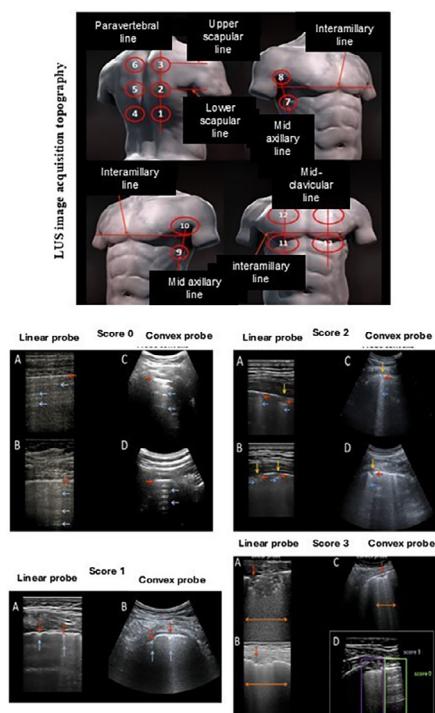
Epidemiological and clinical history data. Qualitative data of 31 participants were evaluated; data were presented as percentage (%). LUS images for each score, obtained with a linear probe (A) and a convex probe (B). Score 0: continuous and regular pleural line (red arrows); horizontal artifacts – A lines (blue arrows). Score 1: indented pleural line (red arrows); sparse B lines present (blue arrows). Score 2: pleural line with interruptions (yellow arrows); below the pleural line interruption points, small areas of consolidation are present (red arrows), associated with areas of coalescent vertical artifacts (B lines) (blue arrows). Score 3: pleural line with extensive interruptions; Below the points of discontinuity of the pleura, extensive pulmonary consolidations can be found (red arrows), associated with generalized areas of “white lung” (orange arrows). Htn, Hypertension; DM, Diabetes Mellitus; CVA, Cerebral Vascular Accident; DVT, Deep Vein Thrombosis; Trach, Tracheostomy; LUS, Lung Ultrasound; Consol, Consolidation; PT, Pleural Thickening; PE, Pleural Effusion; DD, Depression disorder; MP, Muscle Pain; ML, Memory Loss; HL, Hair Loss; ACT, Anticoagulation; RRT, Renal Replacement Therapy; Weak, Body Weakness.
